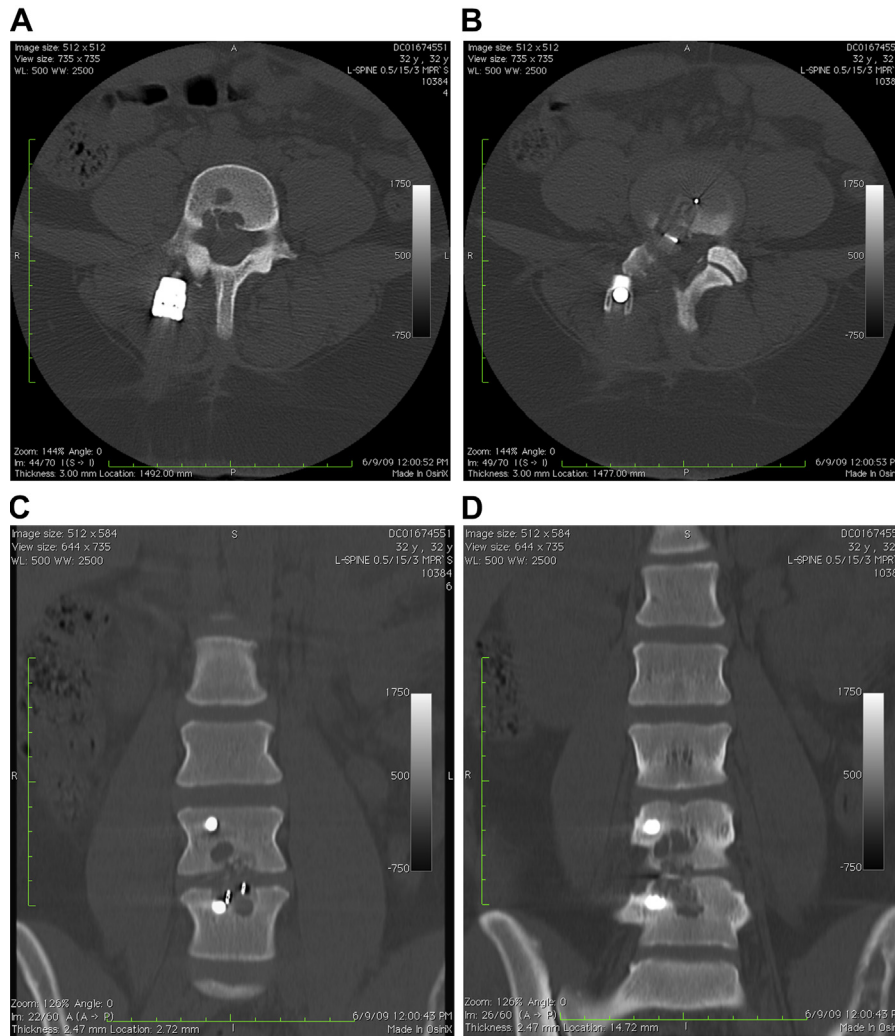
Axial (A, B) and coronal (C, D) computed tomography images demonstrating vertebral osteolysis at L4/L5. Case migration (B) and subsidence (C) are also observed in conjunction with osteolysis.
